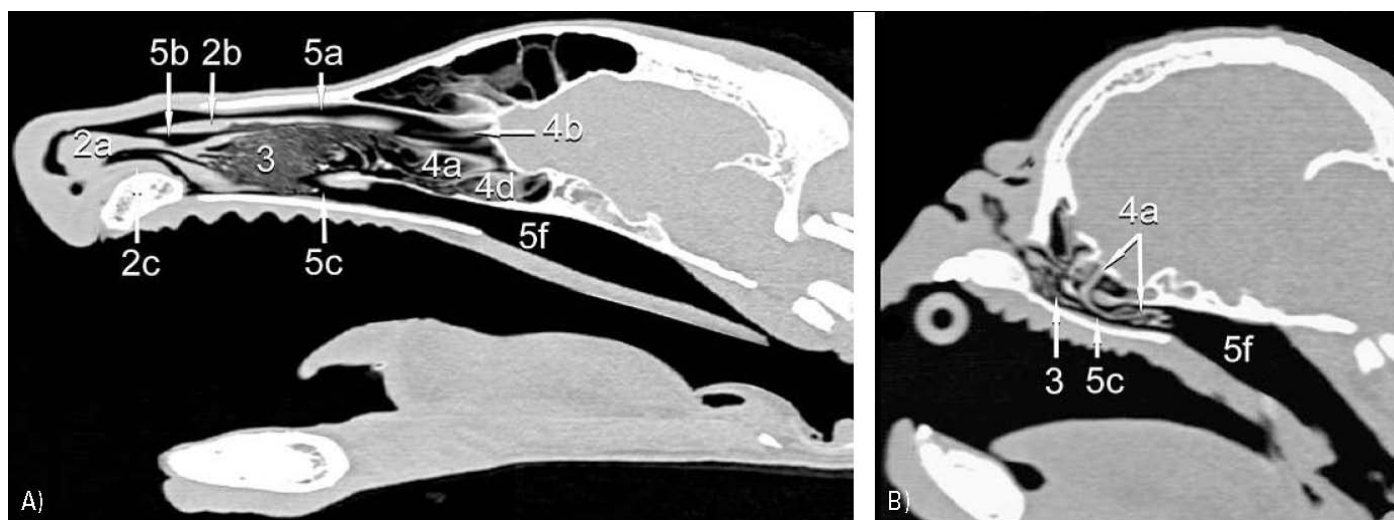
Sagittal CT-Scans of a normocephalic and a brachycephalic head (OECHTERING et al. 2007)
